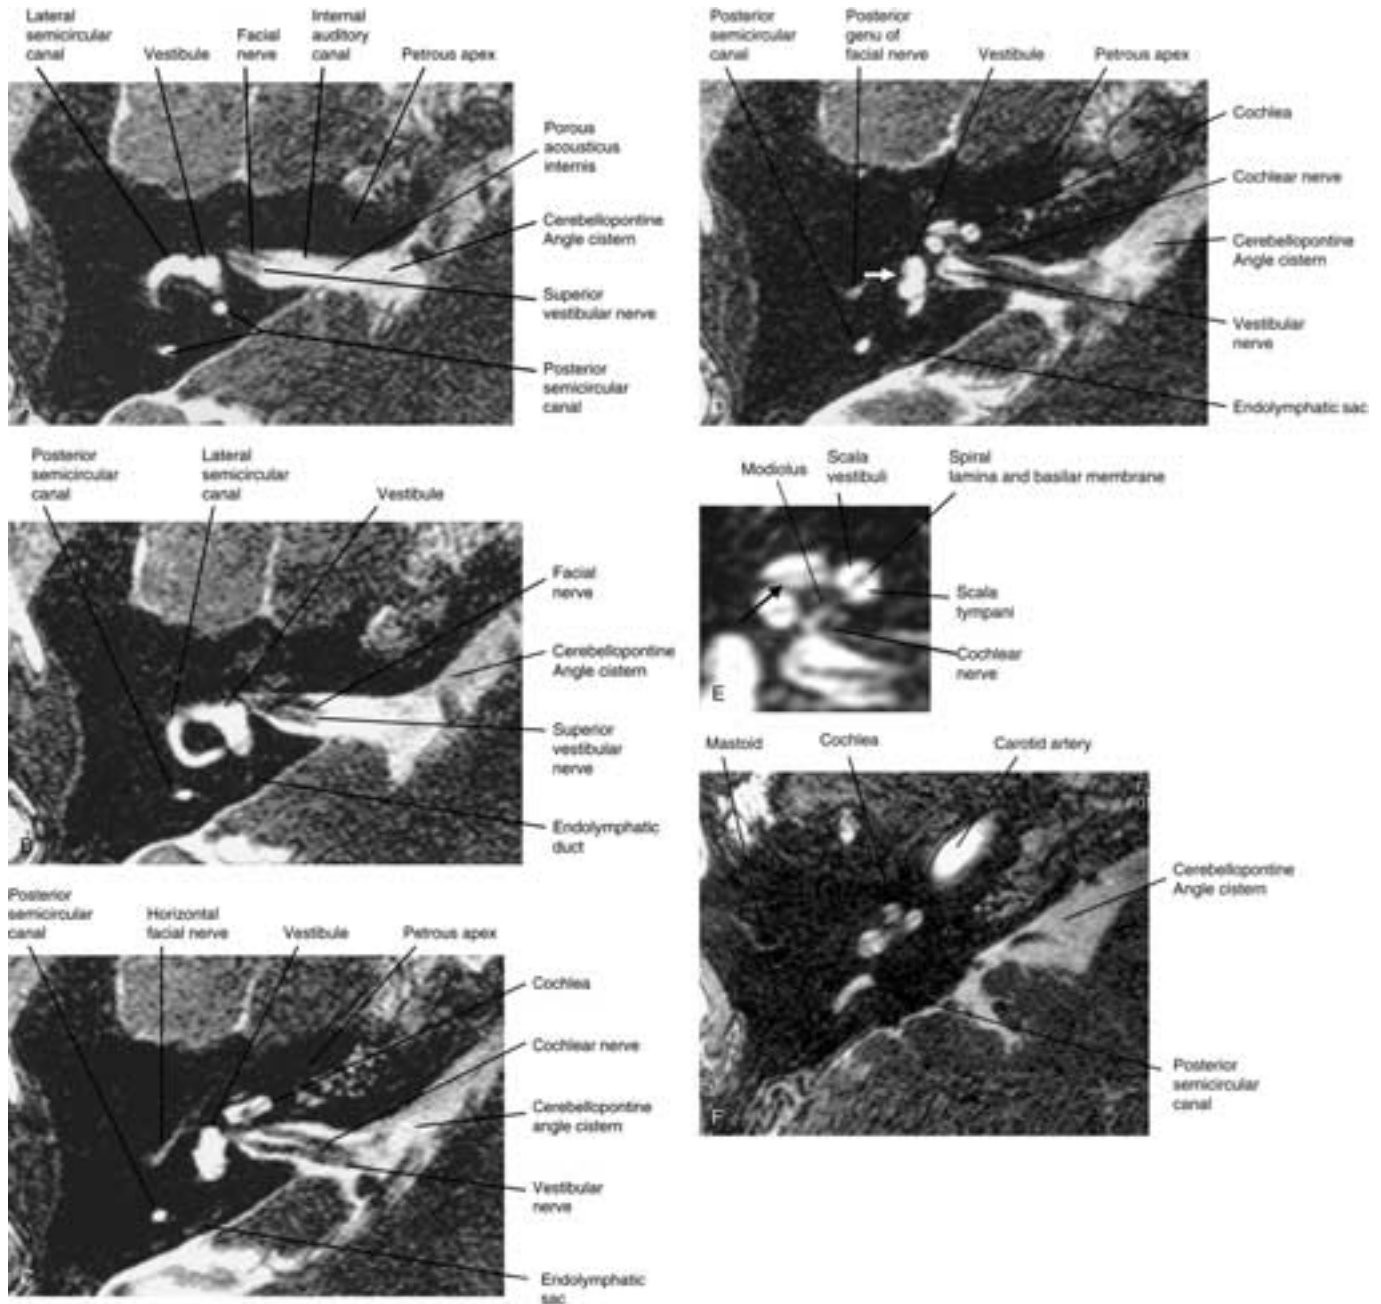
A to F, Axial MR imaging, IAC level. Each axial image is a gradient echo steady-state SIMCAST 0.7 mm thick, 1024 × 1024 matrix axial section of the right temporal bone. The images appear to be T2-weighted, although the origin of the contrast is more complicated. The CSF and other fluid spaces demonstrate high signal intensity. The brain is intermediate in signal intensity, and the bone and pneumatized air spaces are signal voids. The IAC contains the seventh and eighth nerves. They are seen as thin, linear low signal intensity structures in the canal. The cochlea, vestibule, and semicircular canals are well seen. This section is not made 30° from the anthropologic baseline, so the complete lateral semicircular canal is not seen. The endolymphatic sac is seen posterior and medial to the posterior semicircular canal. In D the apparent notch (*arrow*) in the margin of the vestibule is susceptibility artifact. E is a magnified view of the cochlea at approximately the same level as D. Note the interscalar septum (*arrow*). Compare to the image provided by CT in [Figures 19-10](#) and [19-11](#).
